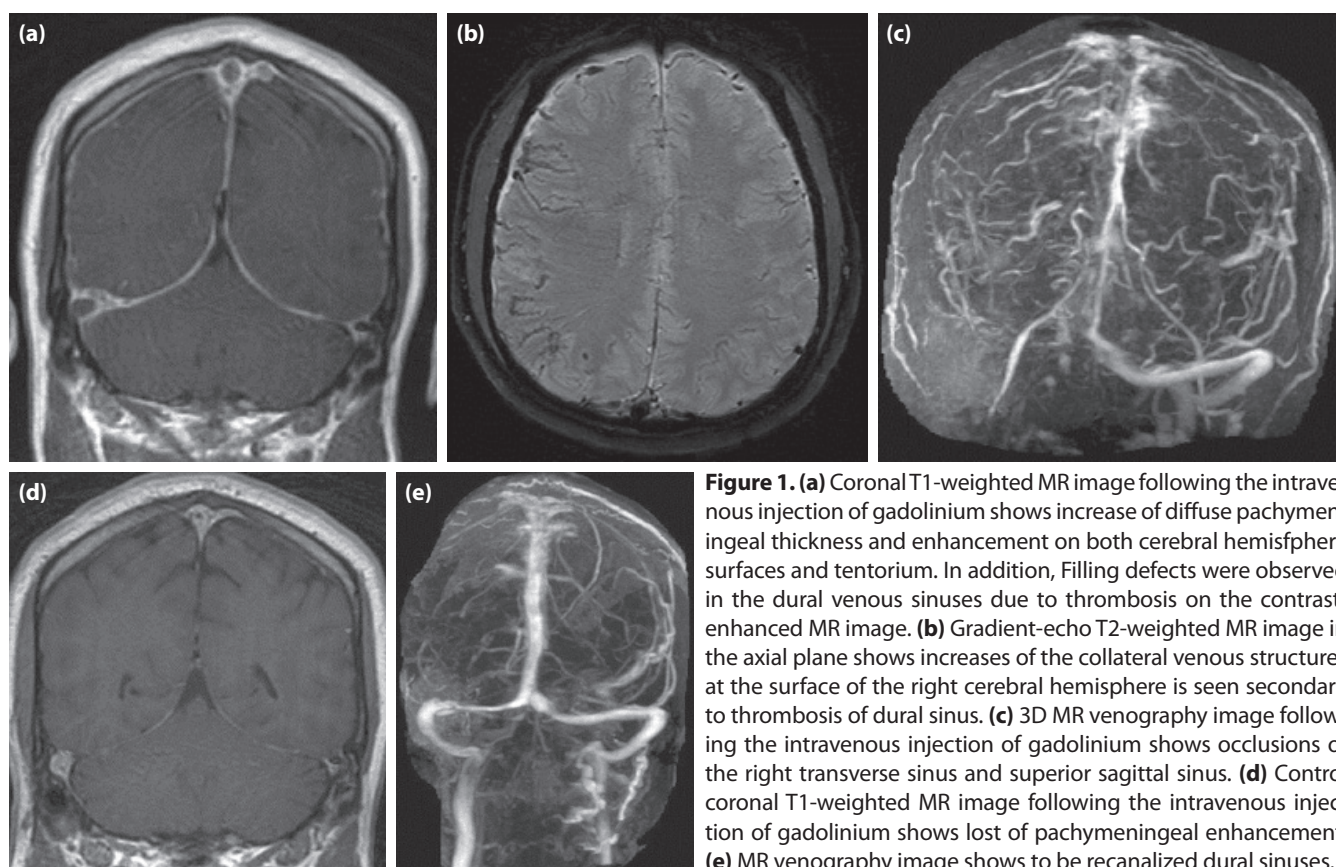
(a) Coronal T1-weighted MR image following the intravenous injection of gadolinium shows increase of diffuse pachymeningeal thickness and enhancement on both cerebral hemisphere surfaces and tentorium. In addition, Filling defects were observed in the dural venous sinuses due to thrombosis on the contrast-enhanced MR image. (b) Gradient-echo T2-weighted MR image in the axial plane shows increases of the collateral venous structures at the surface of the right cerebral hemisphere is seen secondary to thrombosis of dural sinus. (c) 3D MR venography image following the intravenous injection of gadolinium shows occlusions of the right transverse sinus and superior sagittal sinus. (d) Control coronal T1-weighted MR image following the intravenous injection of gadolinium shows lost of pachymeningeal enhancement. (e) MR venography image shows to be recanalized dural sinuses.
